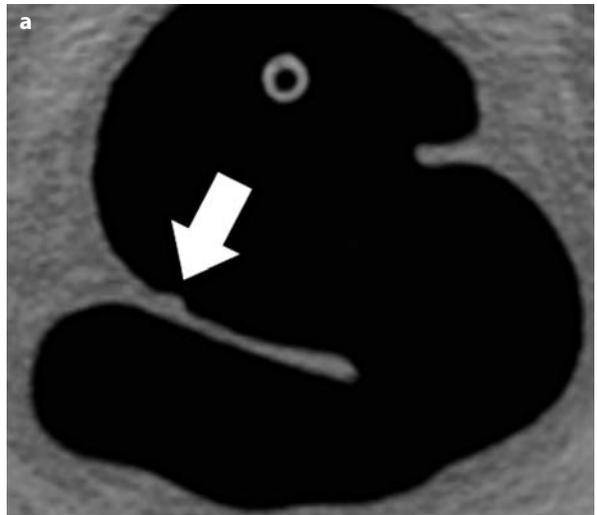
a, b. A 4-mm tubular adenoma in the rectum (arrow). CT colonography with the patient in the prone position with 2D (a) and 3D (b) evaluation
